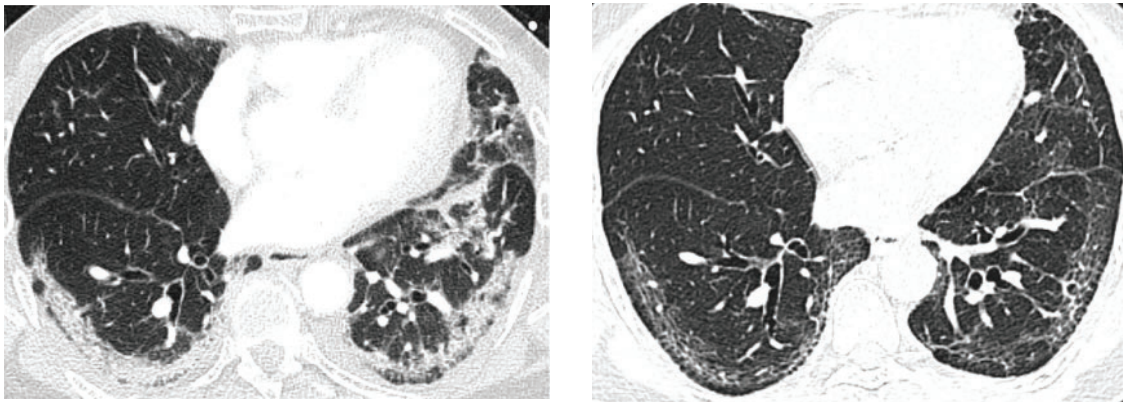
CT scans in a 73-year-old man with COVID-19 demonstrate resolution of subpleural consolidation with residual reticular and fibrotic changes.
